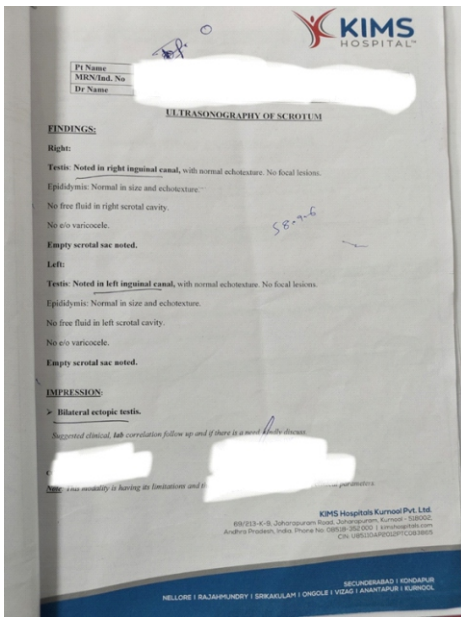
Ultrasound scan image of the scrotum showing both the testes located within their respective inguinal canals, confirming the diagnosis of Bilateral undescended testes.
